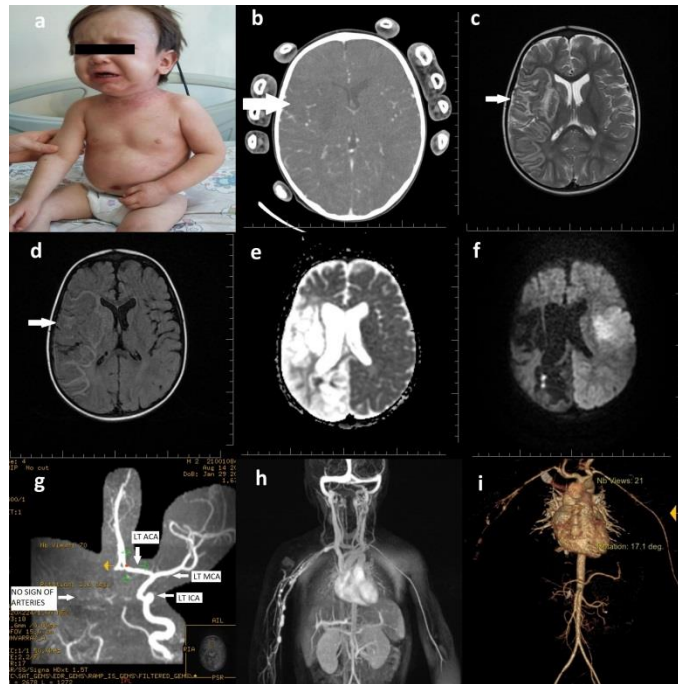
a) patient image (parental permission was obtained), b) initial T1 brain MR; hypointense large subacute infarct area in the right cerebral hemisphere corresponding to the watershed area of the middle cerebral artery, c) axial T2 and d) T2 flair image; subacute hyperintense appearance of the same infarct area, e) three months later, brain ADC image; hyperintense appearance including right hemisphere frontotemporoparietal and occipital lobes, lentiform and caudate nuclei in chronic stage, f) four months later, brain DWI image; large hypointense infarct area in the right hemisphere (chronic stage) but hyperintense new infarct area on the left MCA watershed area, g) brain MR angiography; right ICA and MCA could not be visualized but ACA was visualized thin calibration. Left ACA, MCA, contours and signal intensities were normal, h) one year later, right subclavian MR angiography; multiple aneurysmatic dilatations in the right brachial artery trace, i) upper extremity and abdomen 3D CT angiography; the entire aorta is in normal calibration, and the right common carotid is thinner than the left. Multiple aneurysms are observed in the right brachial artery and its profunda branch.
